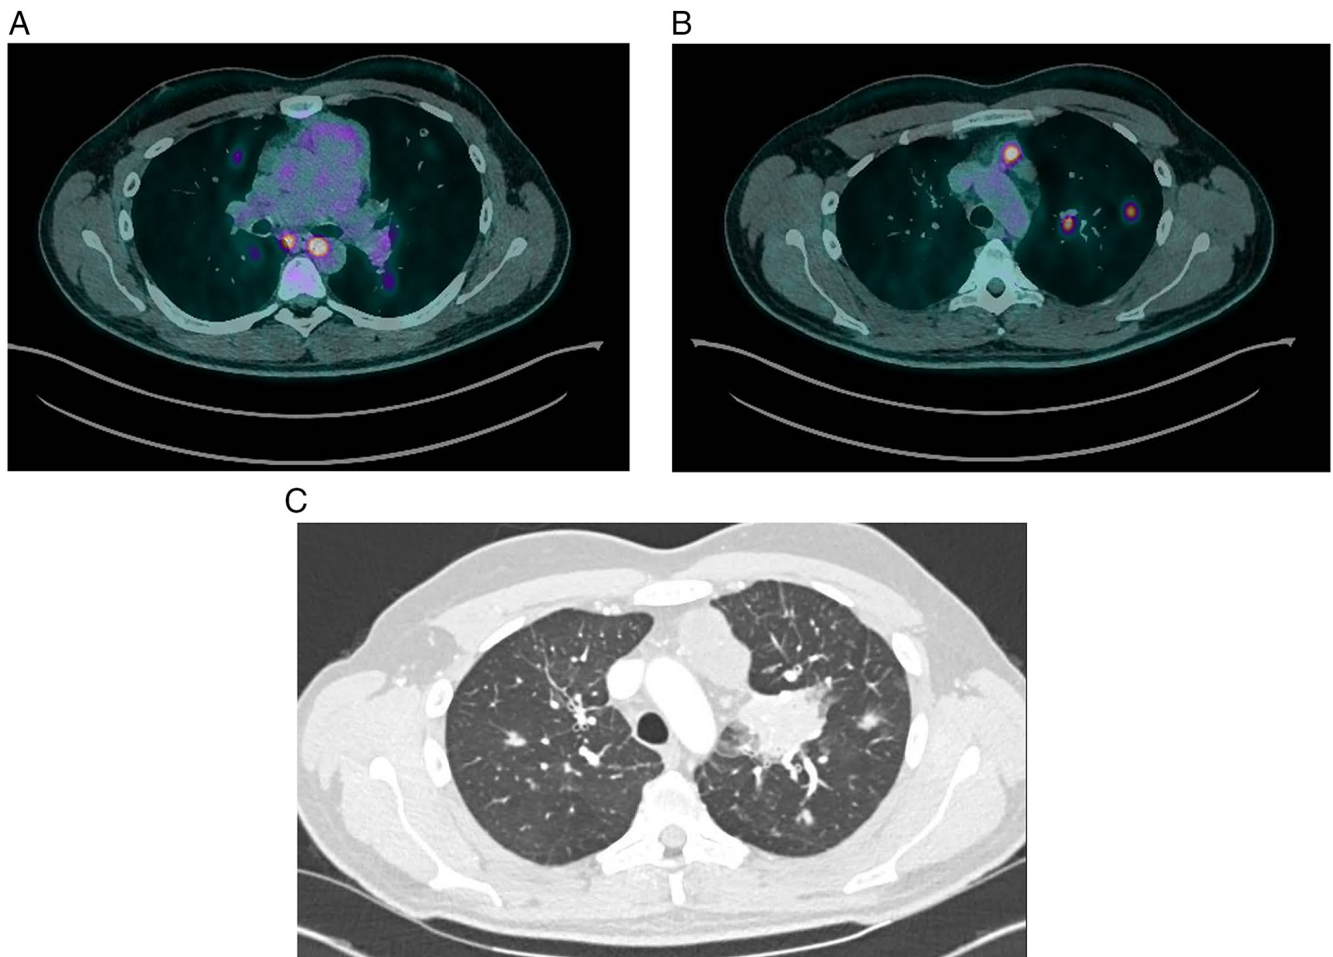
Radiological evidence of therapeutic response and subsequent disease progression. (A) Partial metabolic response (3 months of alectinib treatment): PET-CT axial slice at the hilar level showing near-complete disappearance of the previously described hypermetabolic right hilar mass (compared with Fig. 1A). (B) Disease progression (7 months of alectinib treatment): PET-CT axial slice at the level of the aortic arch revealing multiple new hypermetabolic foci, including bilateral pulmonary nodules and anterior mediastinal lymphadenopathy. (C) Further progression (3 months of lorlatinib treatment): Follow-up CT scan (lung window) at the level of the aortic arch showing an increase in size of the left hilar mass and development of multiple bilateral pulmonary nodules. CT, computed tomography; PET, positron emission tomography.
